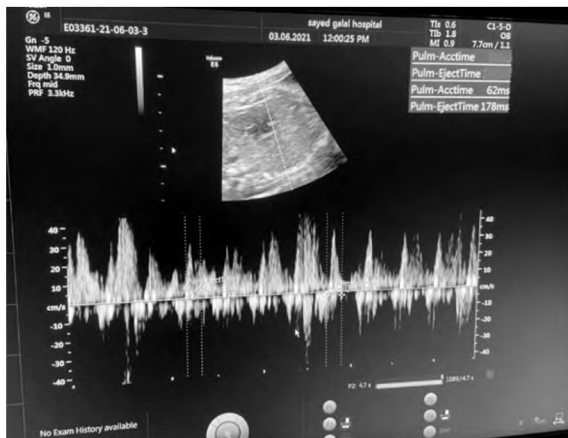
Doppler ultrasound of fetal pulmonary artery showing AT/ET ratio = 0.348.
